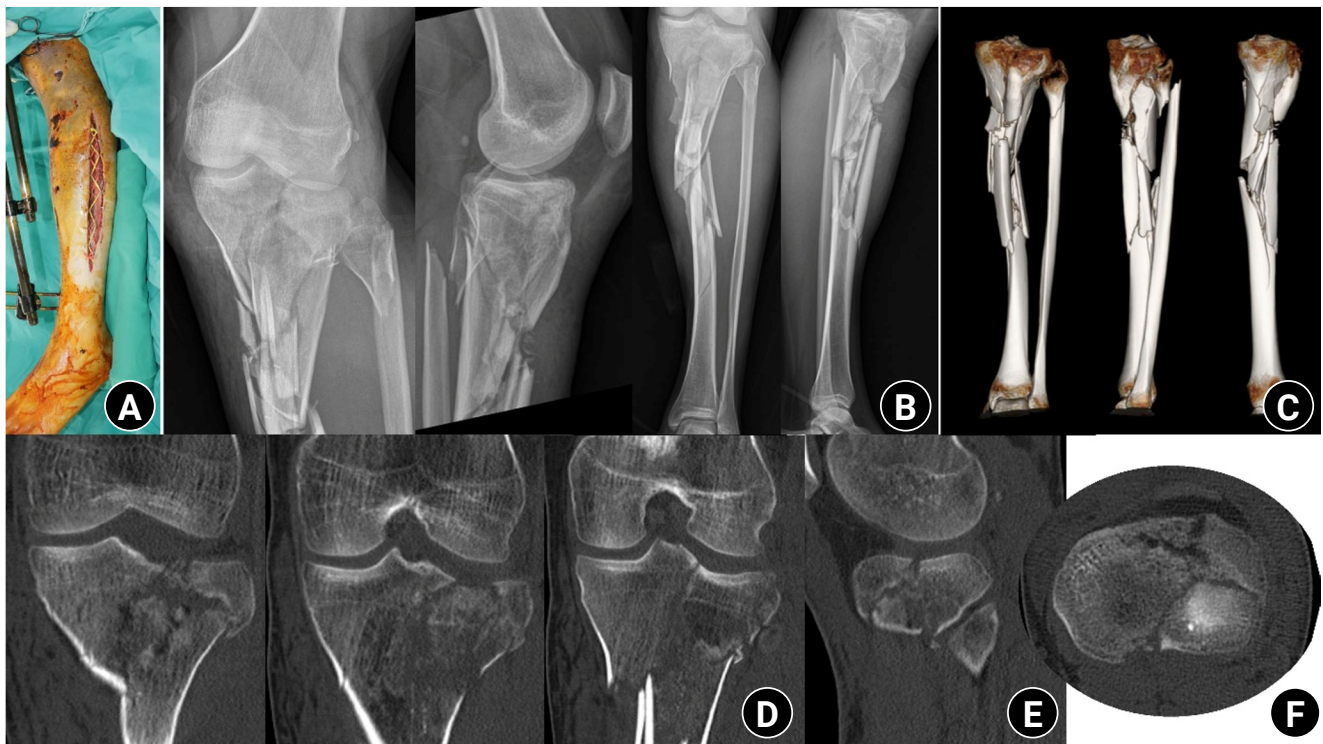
Preoperative photographs, plain radiographs, and computed tomography (CT) images. (A) Clinical photograph showing compartment syndrome of the lower leg with multiple necrotic skin contusions. (B) Preoperative plain radiograph. (C) Preoperative three-dimensional CT image. Preoperative coronal (D), sagittal (E), and axial. (F) CT images demonstrating depression and splitting of the lateral tibial plateau.
